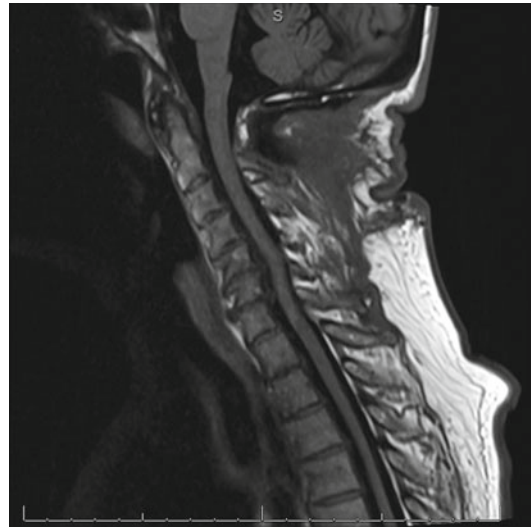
T1-weighted MRI depicting a cavernous malformation
